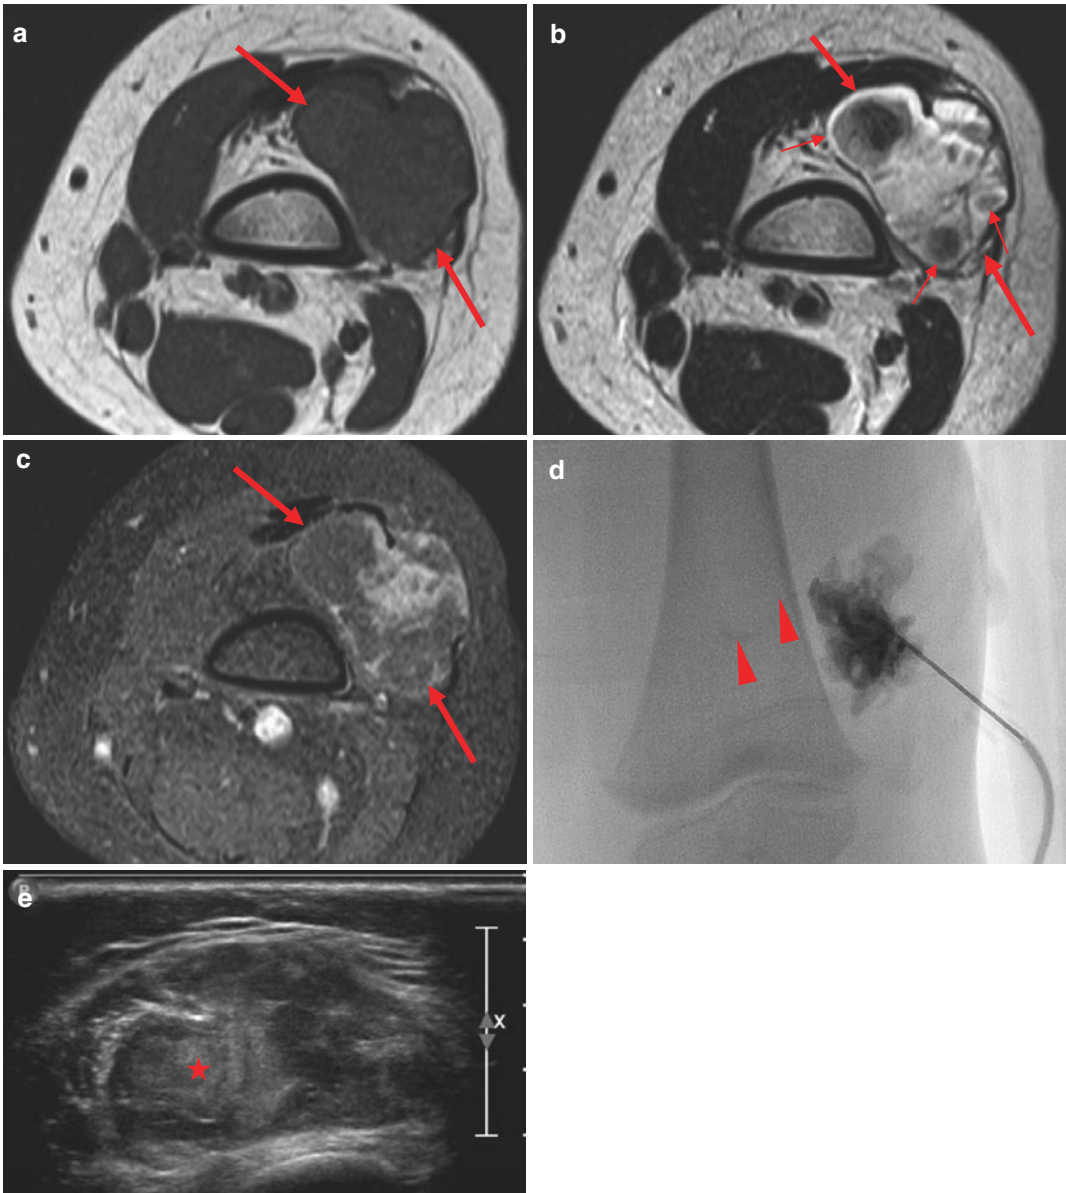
Intramuscular angioma, cavernous type. MR images reveal a circumscribed, multilobulated, multiloculated soft tissue mass (*arrows*) in the vastus lateralis muscle. The mass exhibits inhomogeneous iso- and mildly hyperintensity on T1WI (a), heterogeneous hyperintensity on T2WI (b), and irregular peripheral and some solid enhancement on postcontrast FS T1WI (c). Variably sized T2 hypointense foci (*thin arrows*) represent thrombi.
